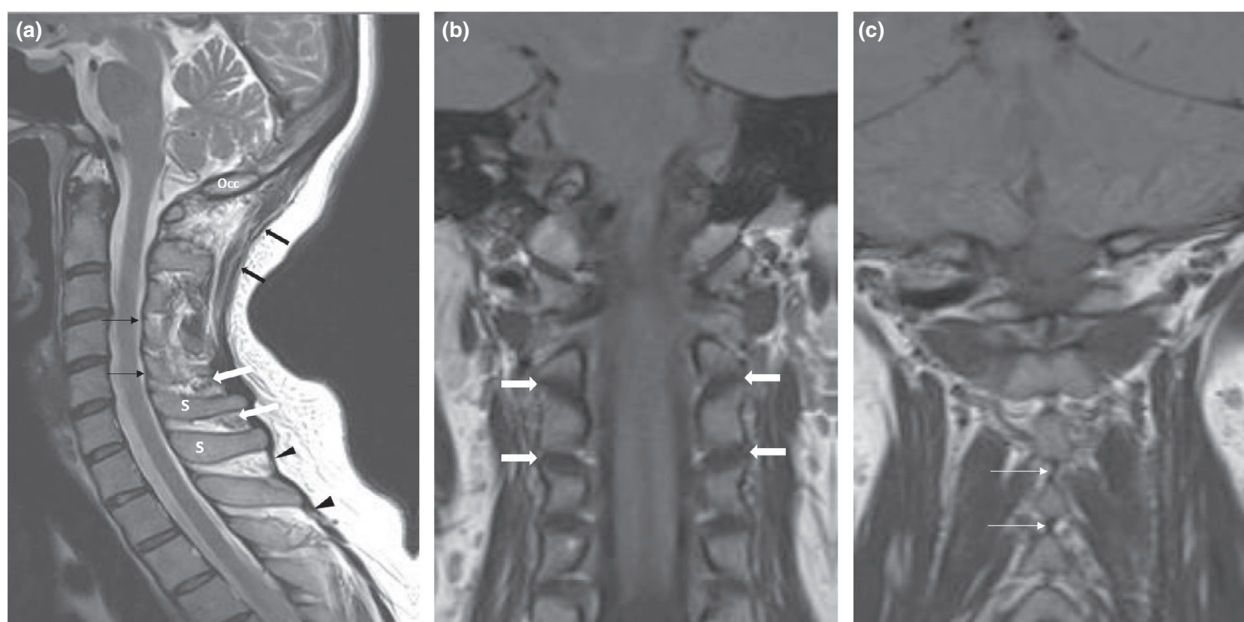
(a) Mid-sagittal T2-W MR image shows the normal nuchal ligament (thick black arrows), ligamentum flavum (thin black arrows), interspinous ligaments (thick white arrows) and supraspinous ligaments (black arrowheads). These ligaments are best seen in the sagittal plane and are normally hypointense on the T1 and T2W images. Ligamentum flavum is seen bridging the lamina of the adjacent vertebrae. The nuchal ligament is depicted as the cranial extension of the supra and interspinous ligaments. The spinous processes (S) and posterior occiput (Occ) are labelled. (b) and (c) coronal T1-W MR images show the normal appearance of facet capsules (thick arrows) and interspinous ligaments (thin arrows).
